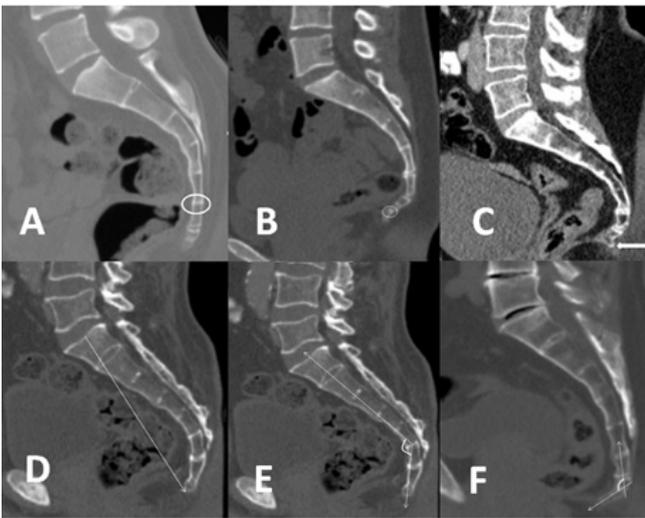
CT images for morphology and morphometry of the sacrococcygeal region. A; Sacrococcygeal fusion. B; Intercoccygeal fusion. C; Coccygeal spicule. D; Sacrococcygeal straight length. E; Sacrococcygeal curvature angle. F; Intercocygeal curvature angle.
